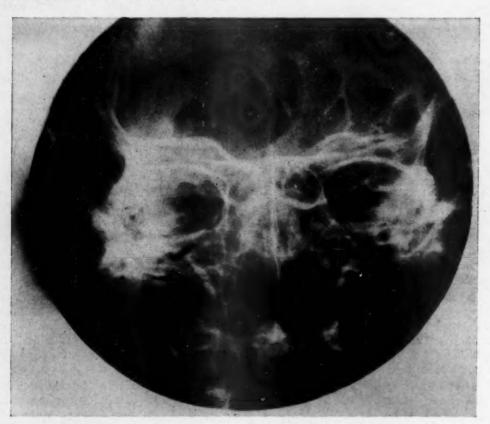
Roentgenogram of the skull on the thirty-fourth day after extraction of the upper right first molar (R-6). There is considerable clouding of the ethmoidal, and right maxillary sinuses. AMM Neg. 78989.
